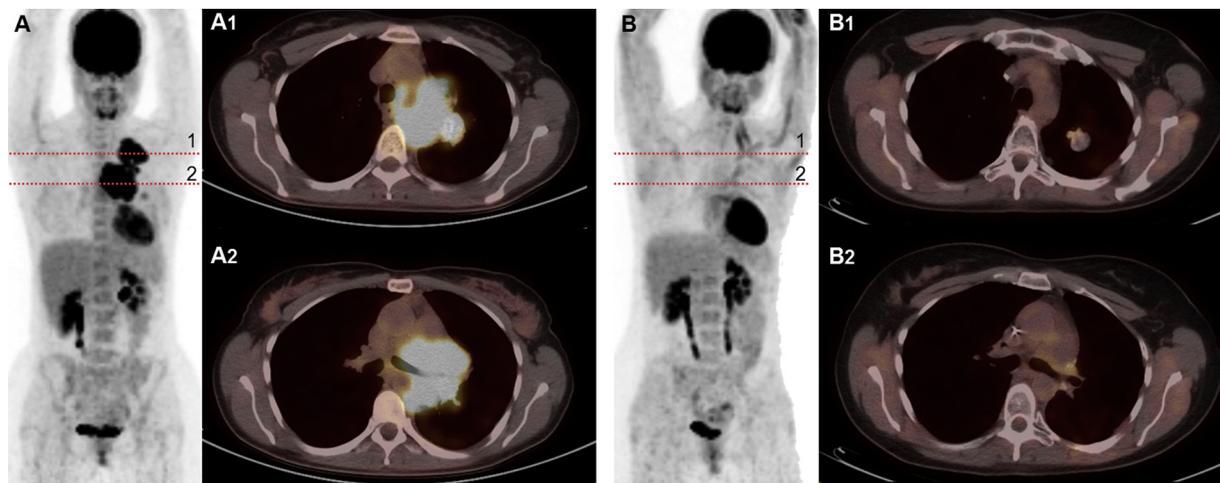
Evaluation by fluorodeoxyglucose positron-emission tomography combined with computed tomography (FDG PET-CT). (A) At diagnosis. The upper left lobe mass was considered as the primary tumor while the hilar mass was considered as regional lymph-node invasion. *Color online.* (B) At the time of surgical feasibility assessment after three cycles of cisplatin and etoposide in first-line therapy, palliative thoracic radiotherapy in second-line therapy, and 14 cycles of nivolumab in third-line therapy. The primary tumor has reduced in terms of both hypermetabolism and size, and the hilar mass has disappeared. *Color online.*
